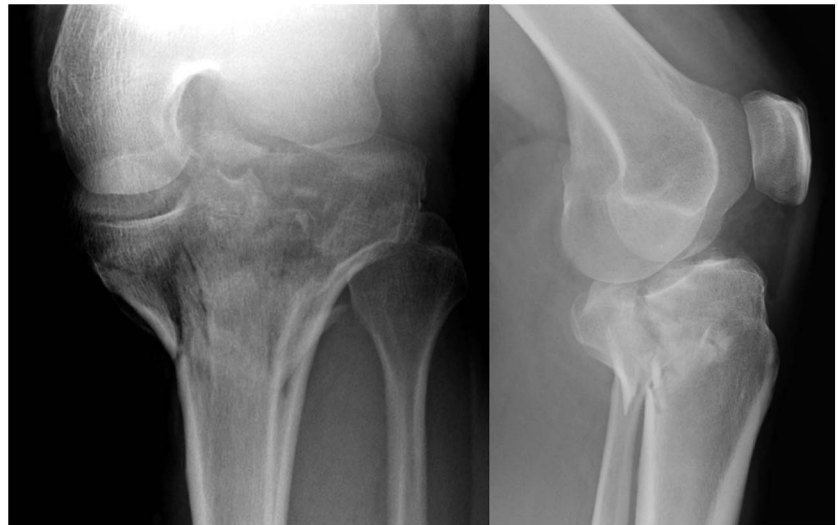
Example of high level of agreement between orthopaedic surgeons and fracture energy calculation. These AP and lateral knee radiographs demonstrate a bicondylar tibial plateau fracture with substantial articular surface comminution and displacement and an associated knee dislocation.
